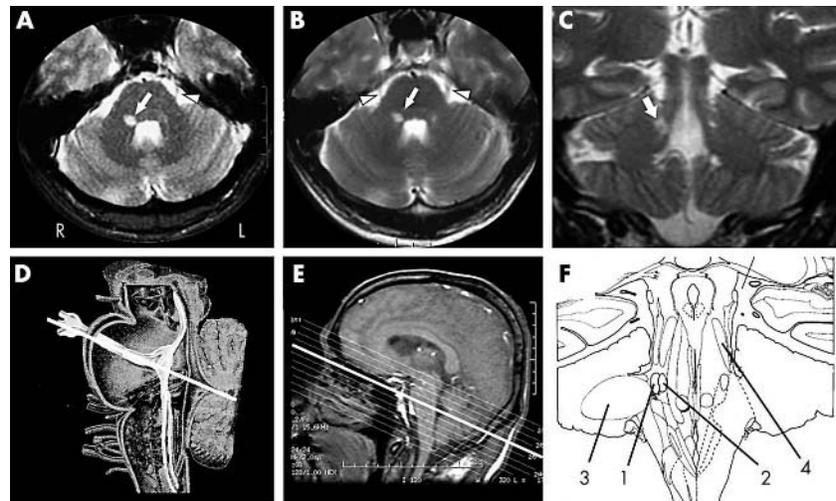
(A) Axial T2* weighted image, (B) axial T2 weighted image, and (C) coronal T2 weighted image, taken 2 weeks after onset, showing a hyperintense lesion (arrow) in the right dorsolateral pontine tegmentum. Extrapontine trigeminal nerves are indicated by arrowheads. (D) A sketch of the intrapontine and extrapontine segments of trigeminal nerves and the trigeminal nuclei. The white thick line indicates the axial slice level used to obtain images (A) and (B). (E) A midsagittal view image with a white thick line indicating slices (A) and (B). (F) A neuroanatomical sketch corresponding to the MR imaging at slice "C". 1, principal sensory trigeminal nucleus; 2, motor trigeminal nucleus; 3, middle cerebellar peduncle; 4, superior cerebellar peduncle.
